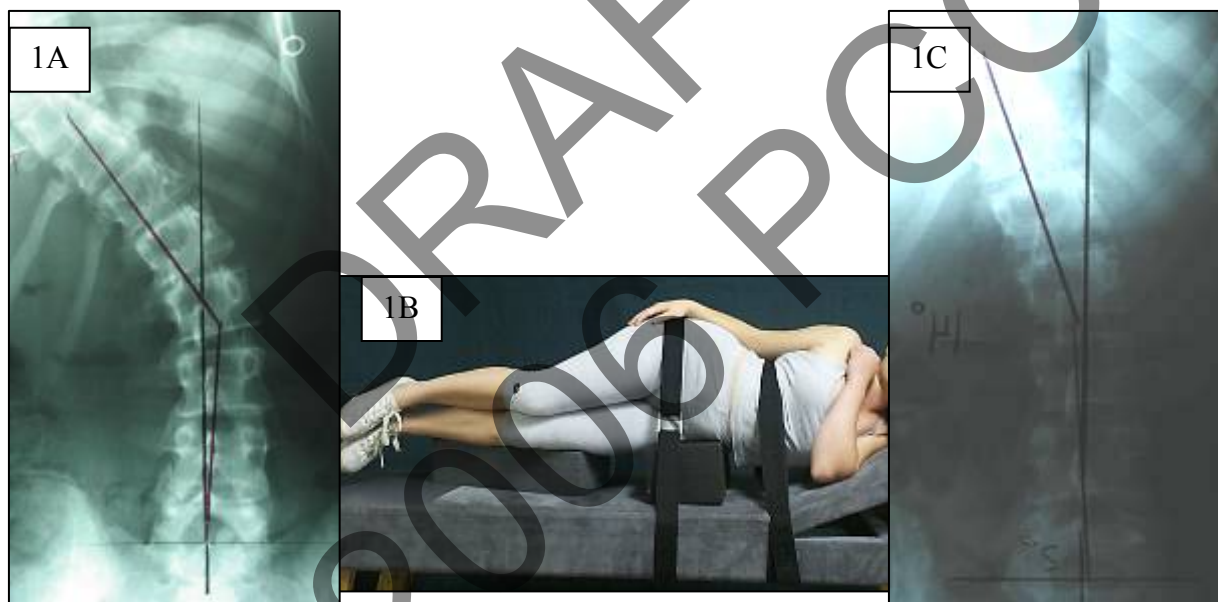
Side lying scoliosis fulcrum-bending stress film. In A, the patient's standing pre-operative AP lumbar radiograph is shown. In B, the patient is positioned in left thoracic translation and right thoracic lateral flexion with movement emphasized to the thoracolumbar spine and an x-ray is taken. In C, the reduction of the curve on the stress film is shown. Reprinted with permission: Harrison CBP Seminars, Inc. 2005-2006.
